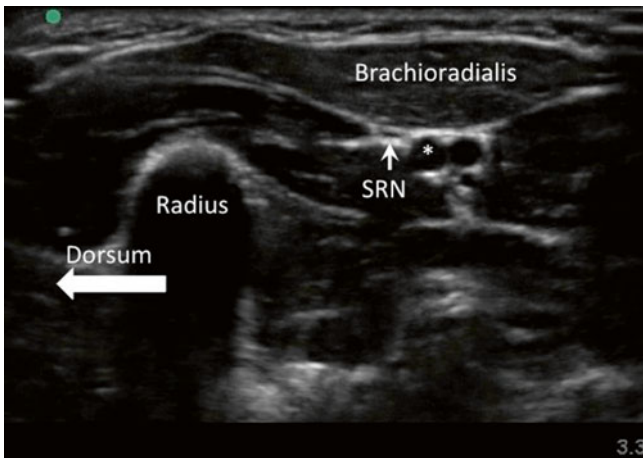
Sonogram of the superficial branch of the radial nerve (SRN) at approximately four fingerbreadths distal to the elbow. The forearm is put in mid-prone position and the probe is placed over the radius. At this level, the SRN is seen in location close to the radial artery (*) beneath the brachioradialis muscle (Reproduced with permission from Philip Peng Educational Series)
